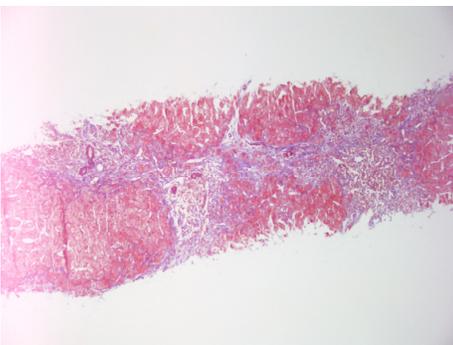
CT scan-guided core-needle biopsy of a cirrhotic liver in 2011
